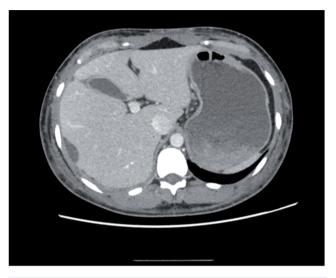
The thoraco-abdominal CT-scan shows the integrity of the gallbladder walls and the presence of peri-hepatic free fluid collections.
